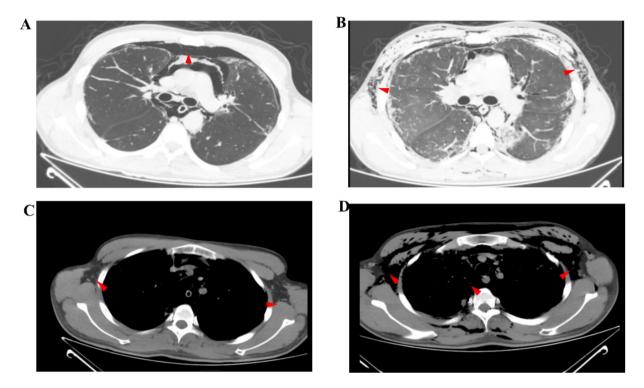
Patient's chest CT scan. A: February 6th chest window imaging; B: February 10th chest window imaging; C: February 6th mediastinal window imaging; D: February 10th mediastinal window imaging. The red arrow points to the lesion
